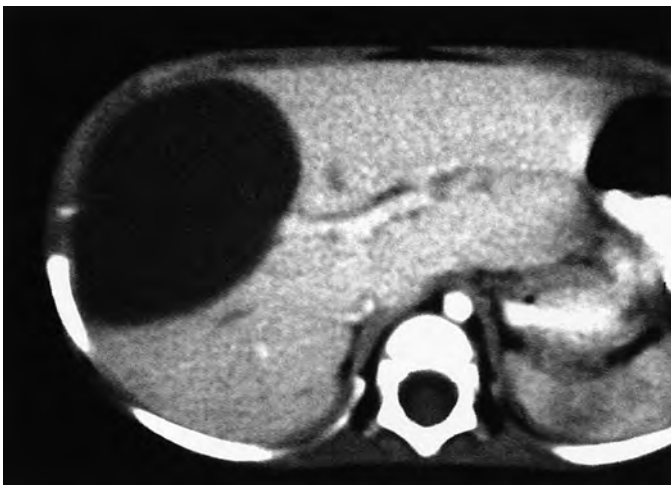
Hepatic cyst. A simple liver cyst in a 6-month-old infant was initially detected on prenatal ultrasound. Continued enlargement led to additional imaging and surgical resection.
